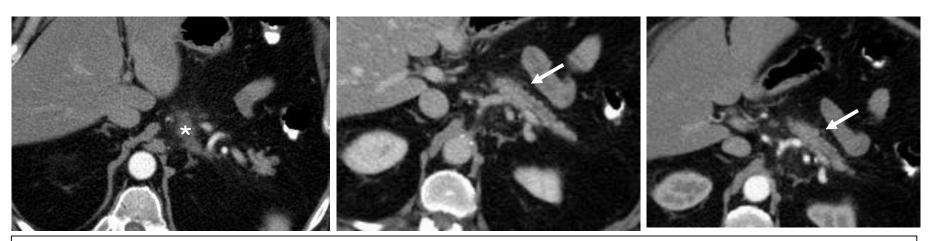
<u>Patient 1</u>. Contrast enhanced CT. Focal inflammatory changes related to mild pancreatitis (*). Segmental ectasia of MPD (arrow) with no evident mass on first CT.
